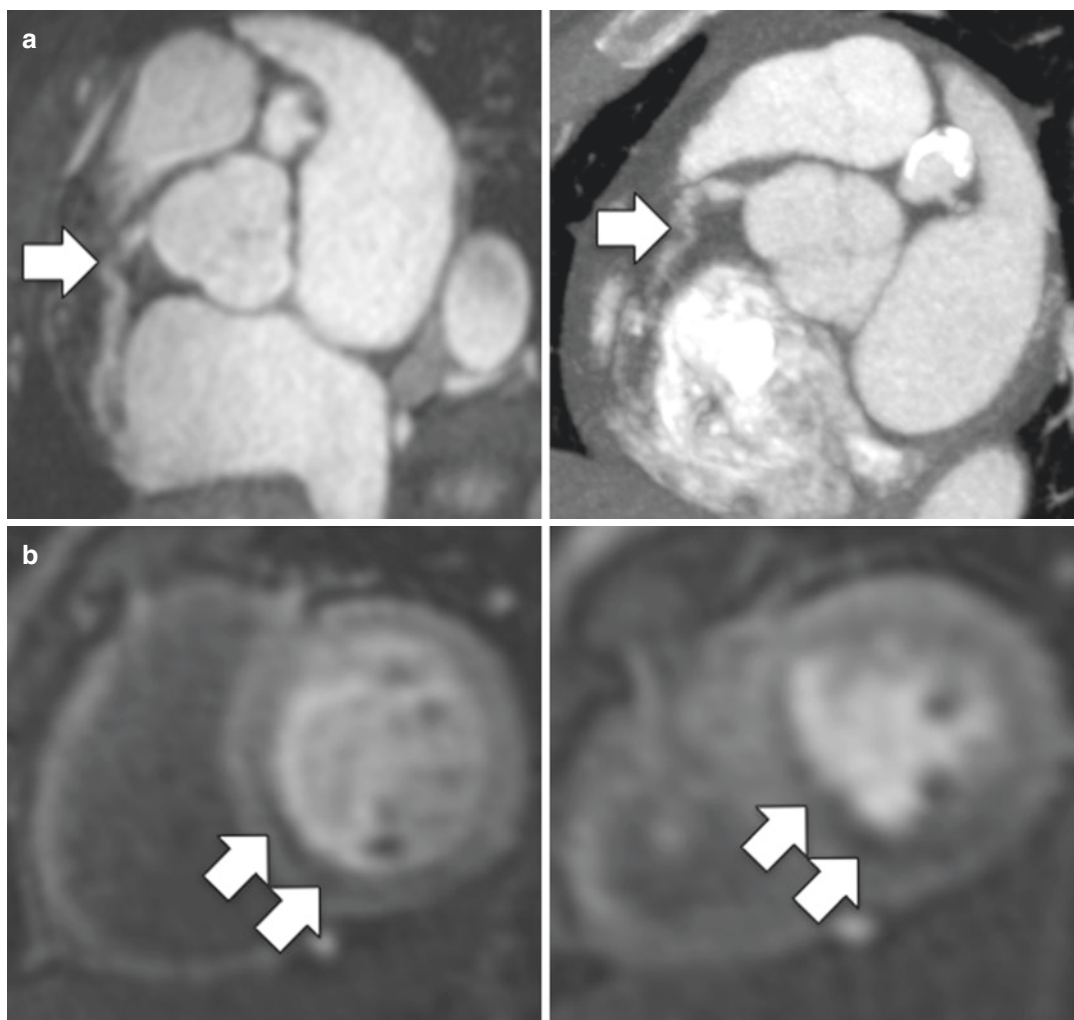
Kawasaki disease with RCA occlusion. (a) Short axis view of the RCA (arrow) on MR angiography (left panel) and cardiac CT (right panel)—the vessel does not look entirely normal on MRA, but the extent of disease is
